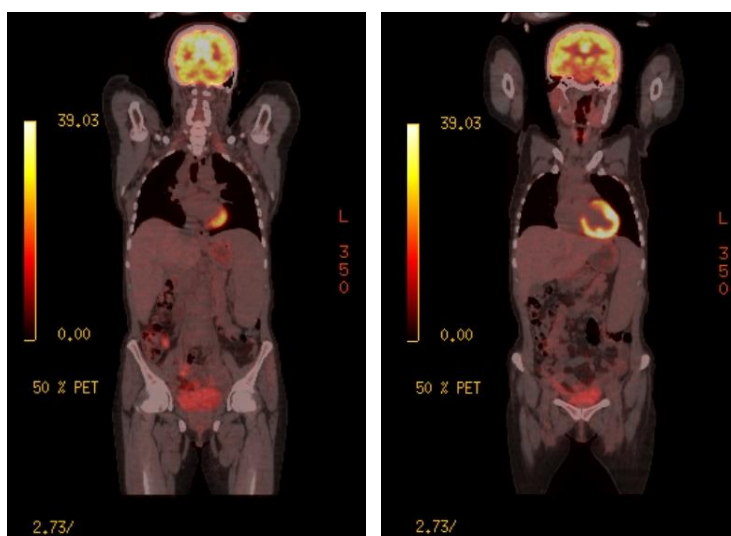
PET/CT images showing the patient's almost complete metabolic response after the third-line treatment (almost complete metabolic response in supra/infradiaphragmatic lymph nodes, significant regression in spleen involvement, complete recovery in pleural effusion in the left hemitarox)
